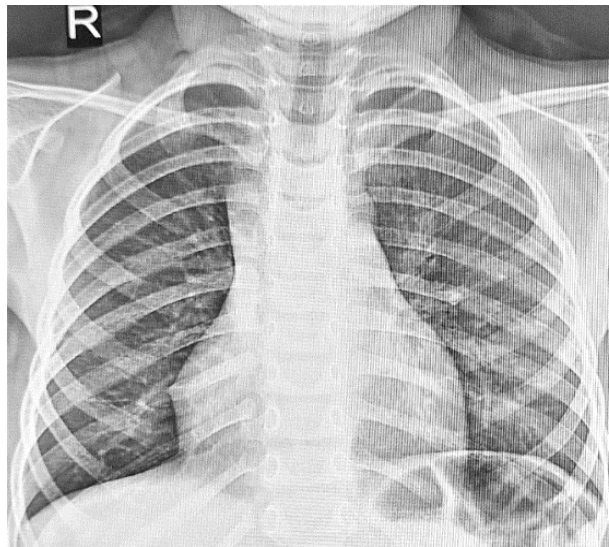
Patient I.S., age: 2 years 7 months, post-lobectomy status for right CCAM, medical record number 3224-213. Plain chest radiograph - complete expansion of the remaining lung.
